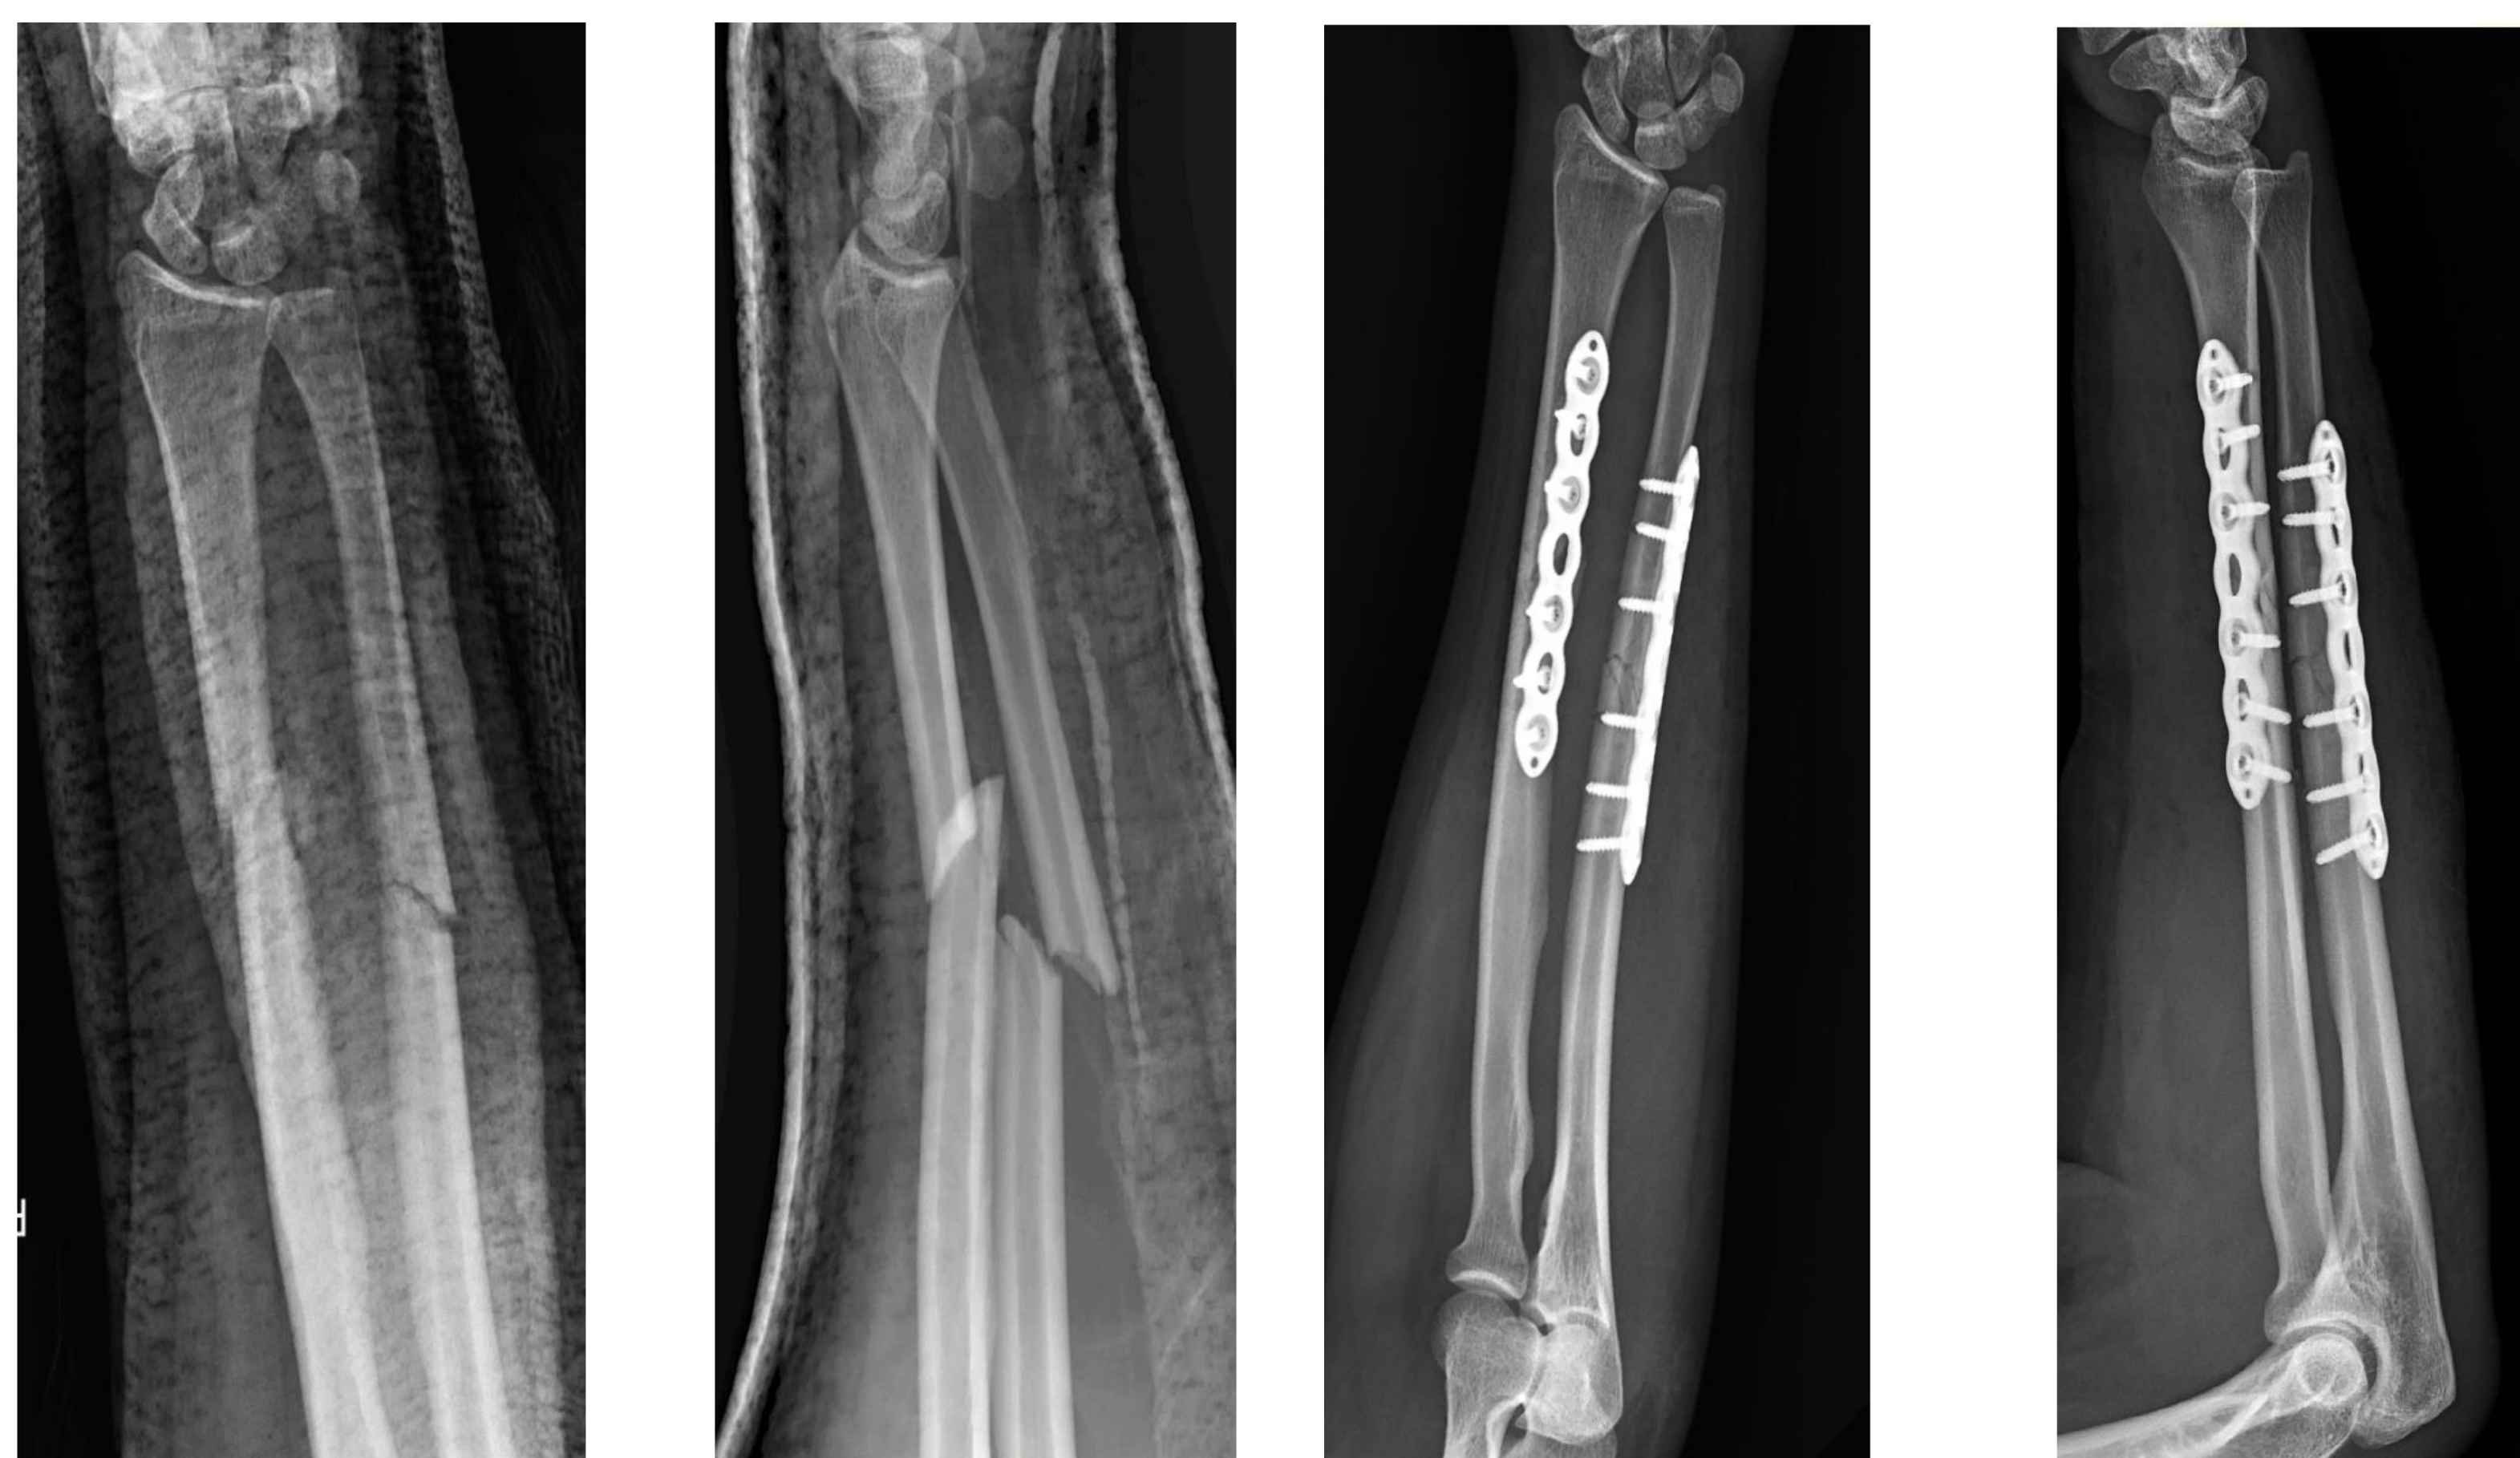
Pre-operative closed reduction X-Ray films
